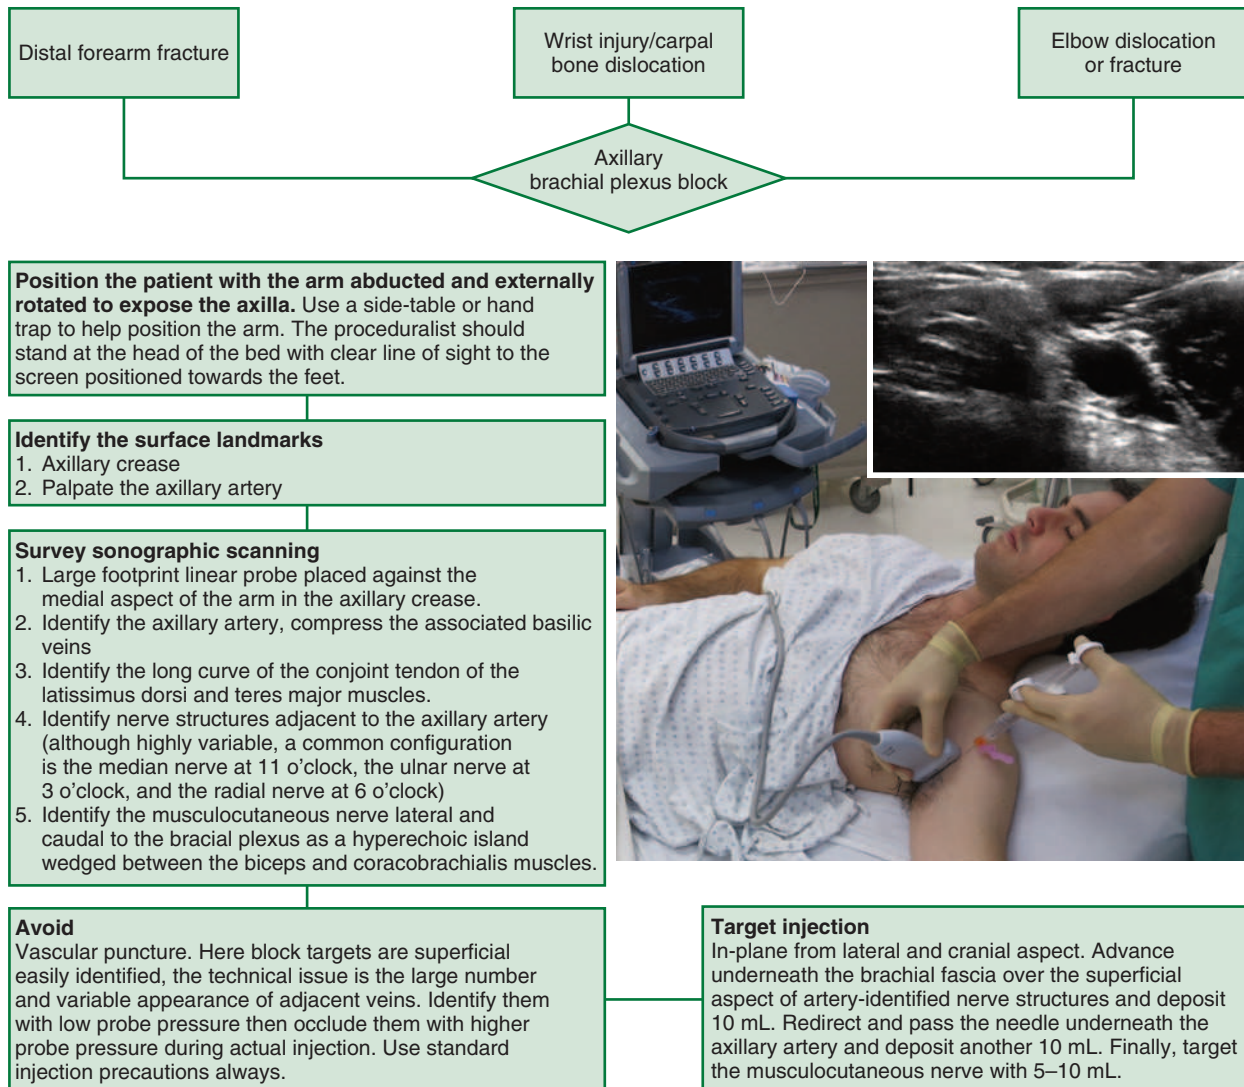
Summary guide for the ultrasound-guided axillary brachial plexus block.
